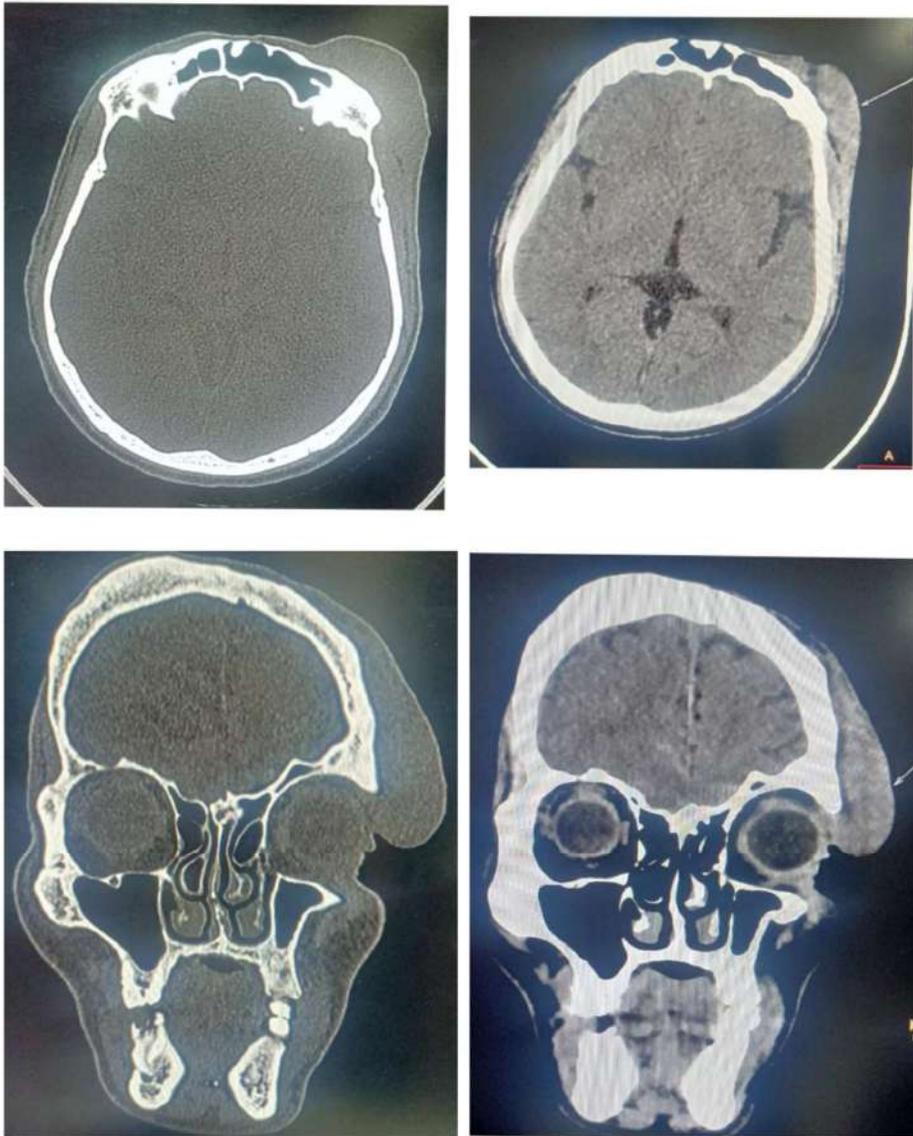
CT scan of brain showing the soft tissue swelling on left frontal and periorbital region.
